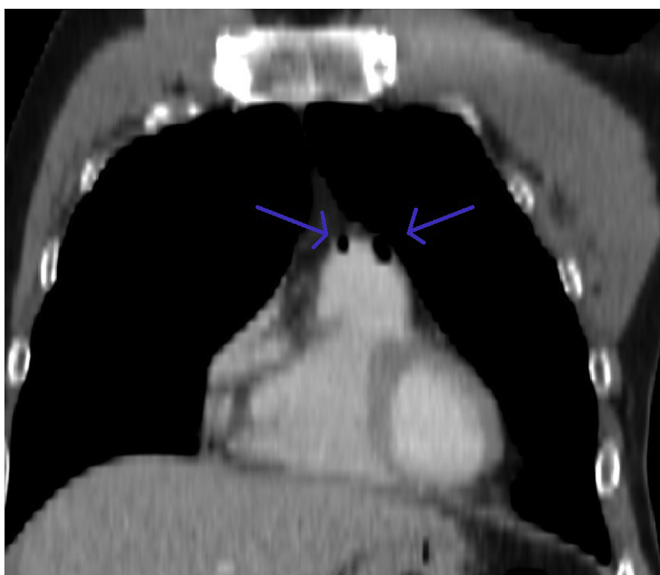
Coronal contrast-enhanced chest computed tomography image showing in the main pulmonary artery air bubbles (arrows).
